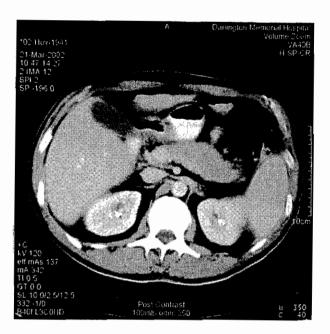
Repeat CT scan demonstrating recanalisation of portal vein after treatment
